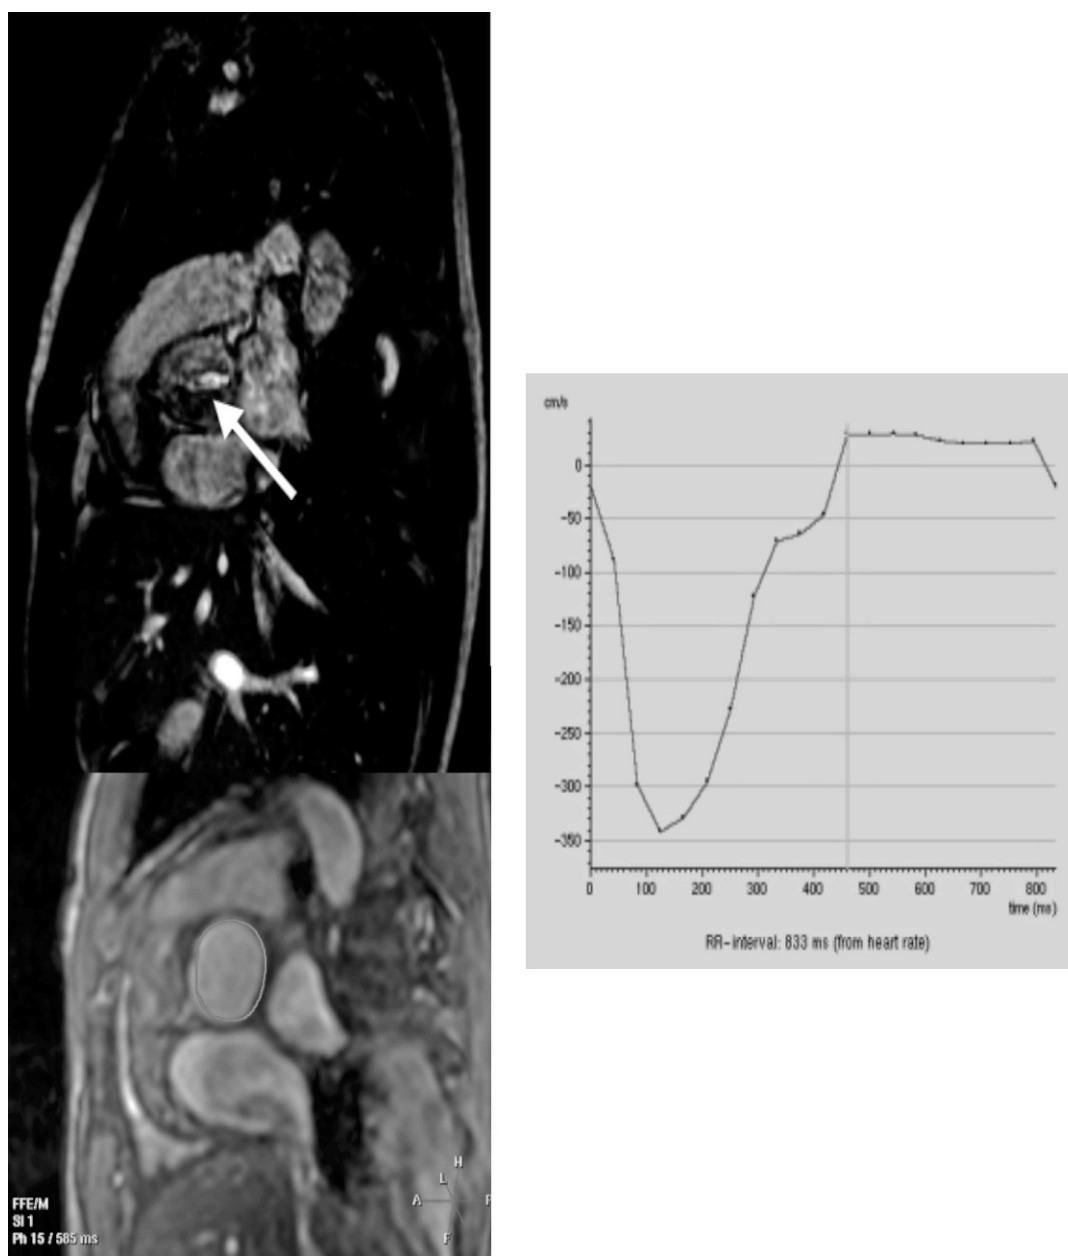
Case: 19-year-old male with bicuspid aortic valve (AV). Cardiac magnetic resonance imaging: Cine image (top image with arrow on bicuspid AV) and velocity encoding contrast imaging (bottom). Graph depicts flow through the valve in systole and diastole. Diagnosis: Bicuspid AV with peak gradient of 40 mmHg and aortic insufficiency with regurgitation fraction of 21%.
